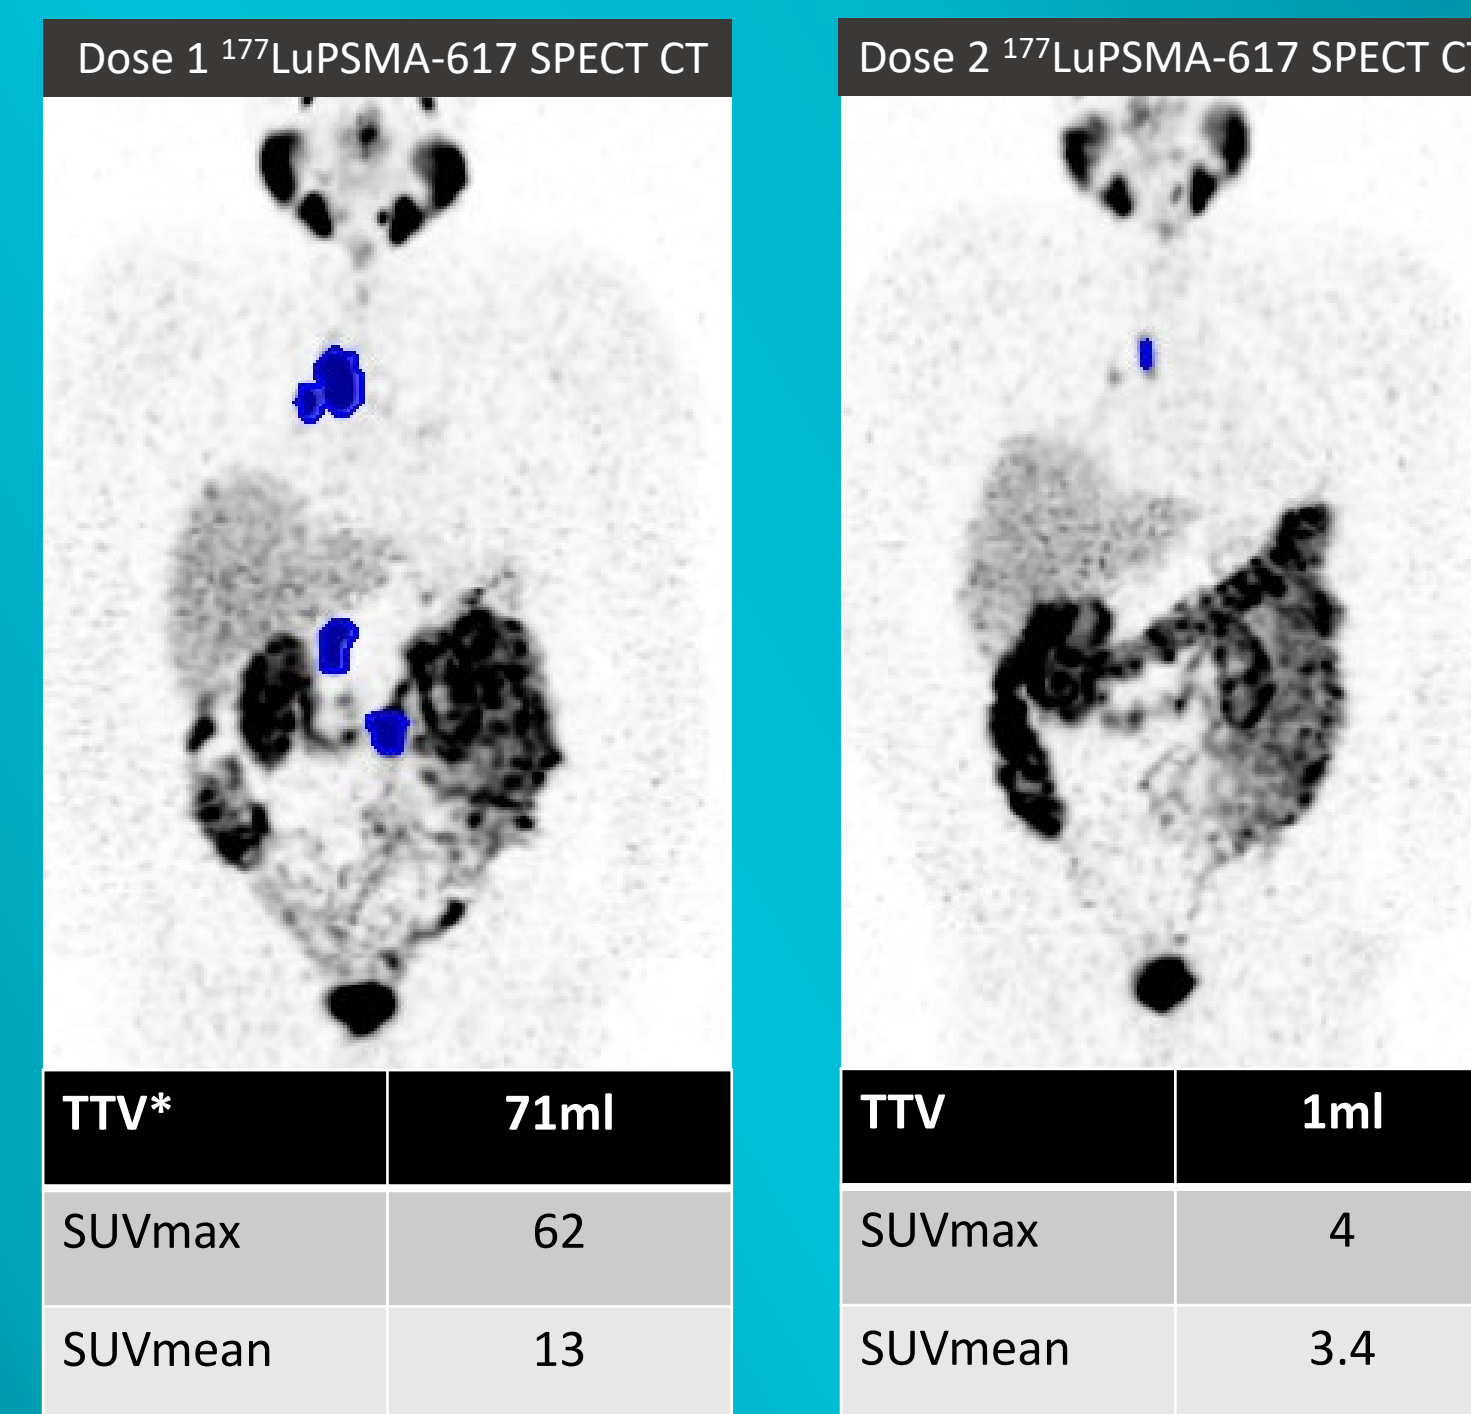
¹⁷⁷LuPSMA-617 SPECT/CT acquisition and analysis is harmonised across trial sites and acquired 24 hours after each dose administered. The value of serial quantitative ¹⁷⁷Lu-PSMA-617 SPECT/CT for response assessment is an important secondary endpoint of the trial. *TTV = total tumour volume
